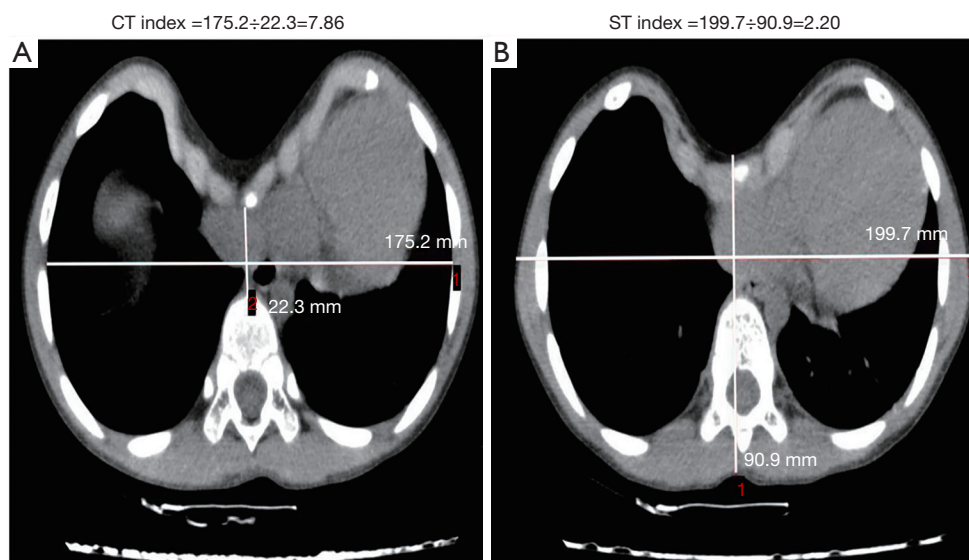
Definition of the computed tomography (CT) index and surface topography (ST) index. Calculations of the CT index (A) and ST index (B).
